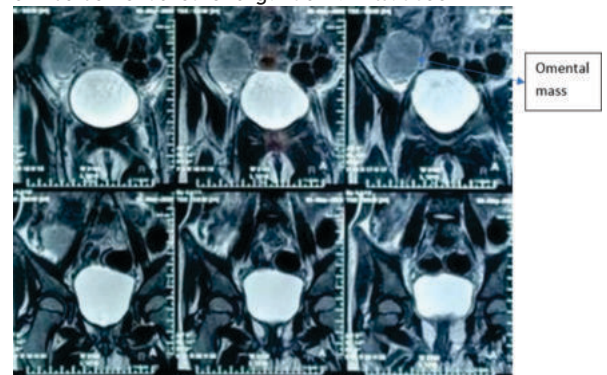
MRI Abdomen Pelvis
